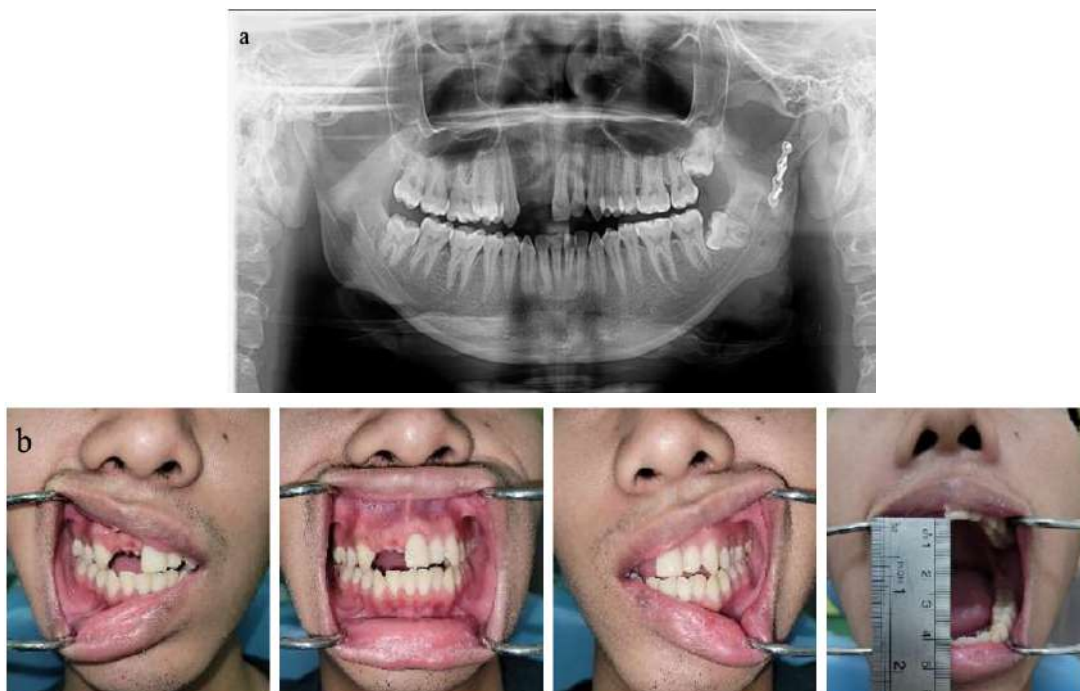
Patient's Evaluation after five months of surgery (a) Panoramic X-Ray (b) Intra oral condition
